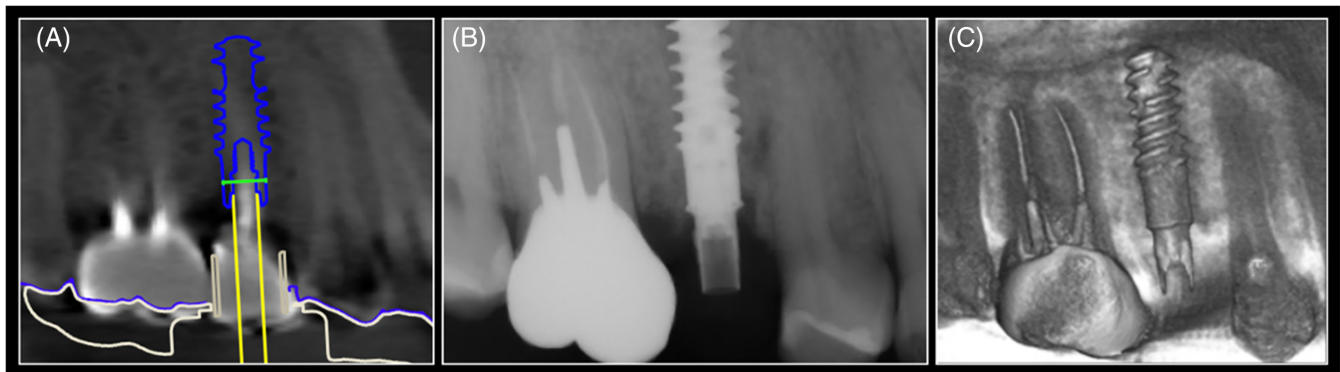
Type 1A implant placement using a straight tissue-level implant to replace an upper second premolar. (A) Virtual planning considering STH and emergence profile; (B) Immediate post-op periapical x-ray; (C) Immediate post-op CBCT reconstruction.
